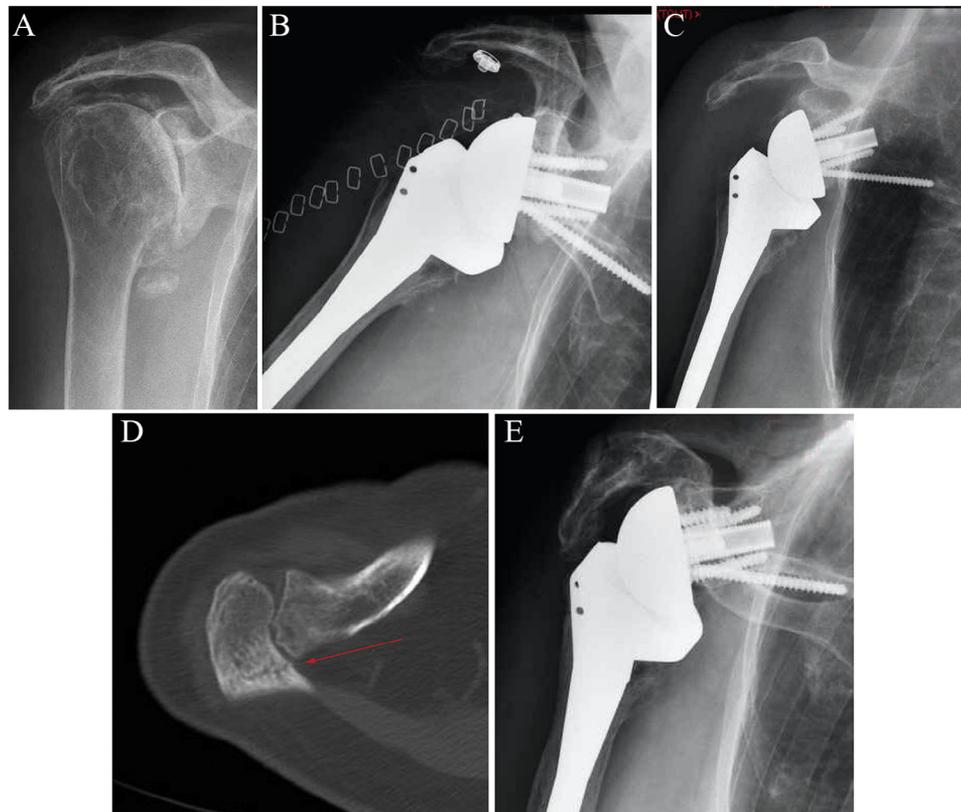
(A) An 83-year-old woman with post-traumatic osteoarthritis underwent reverse shoulder arthroplasty on her right shoulder with intact preoperative acromion and spine. (B) Immediate postoperative radiographs. Two months after the procedure, acromion base fracture was not seen on (C) x-ray images but was diagnosed with a (D) computed tomography scan (arrow) and treated conservatively with an abduction splint. (E) At the 6-year-follow-up, healing was achieved with malunion and acromial tilt.
